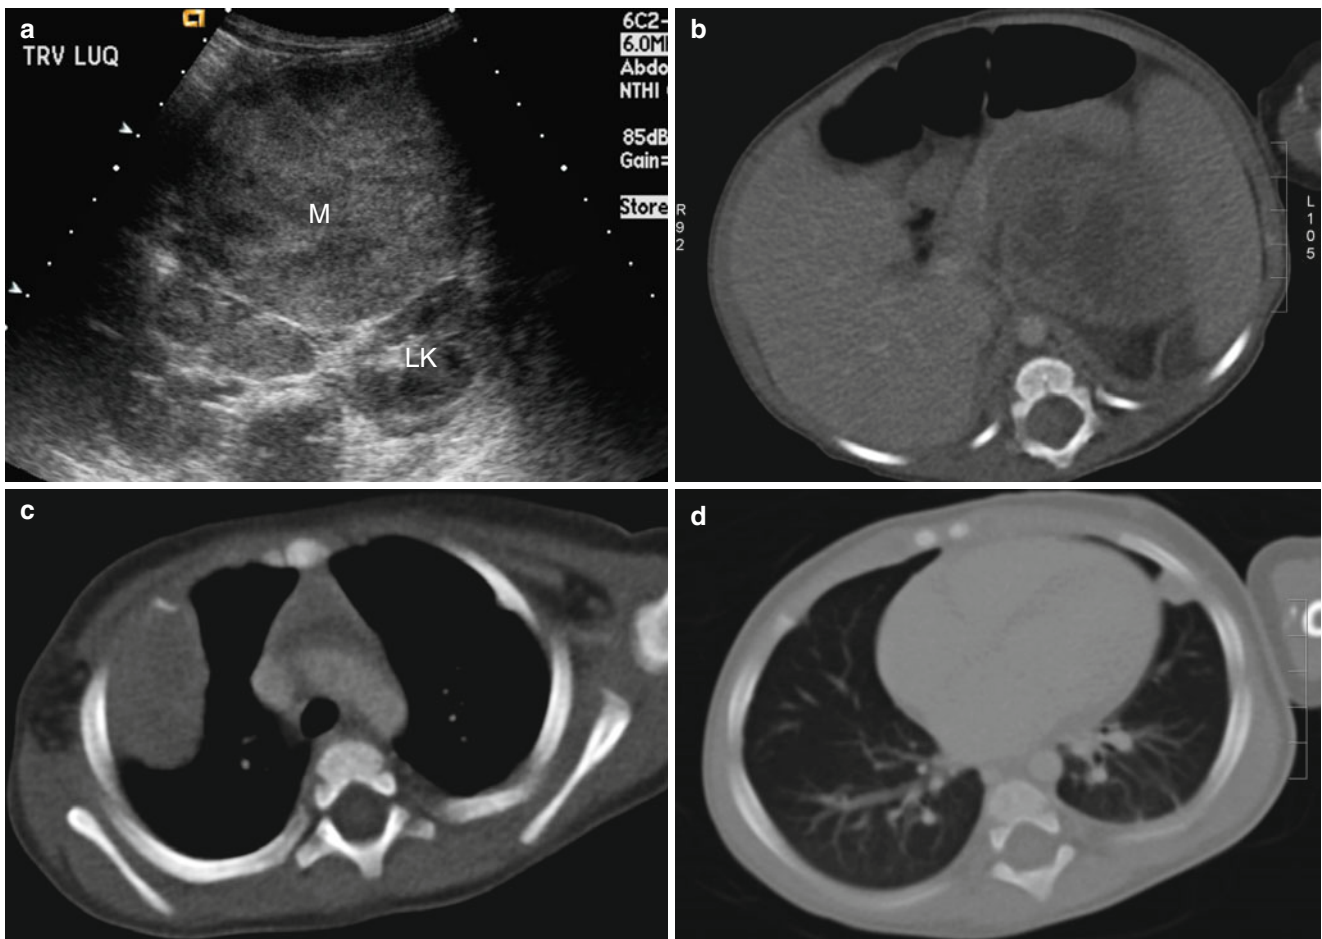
Left adrenal neuroblastoma in a 10-month-old boy. (a) Transverse US scan of the left upper abdomen shows the presence of a large, heterogeneous, right adrenal mass (M) anterior to the left kidney (LK). (b) Axial contrast-enhanced CT image of the upper abdomen
